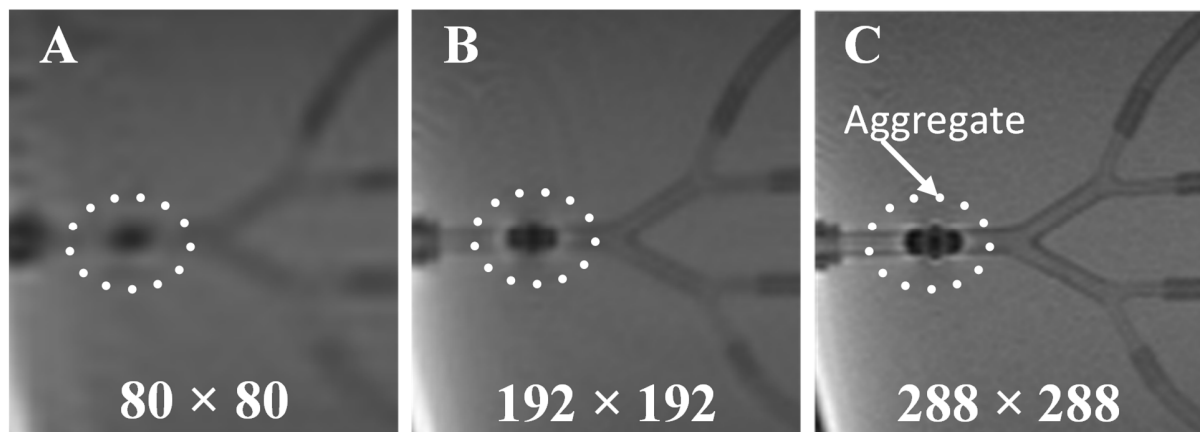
The MR images of an aggregate at three different resolutions.
